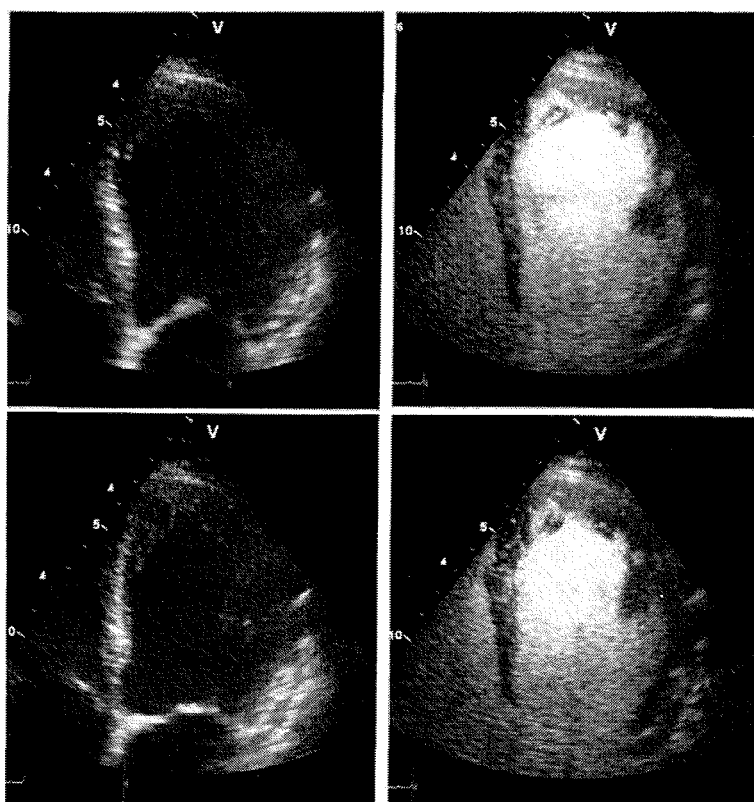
Echocardiographic end-diastolic (top) and end-systolic (bottom) images of the apical four-chamber view from a patient before (left) and after (right) intravenous contrast.
